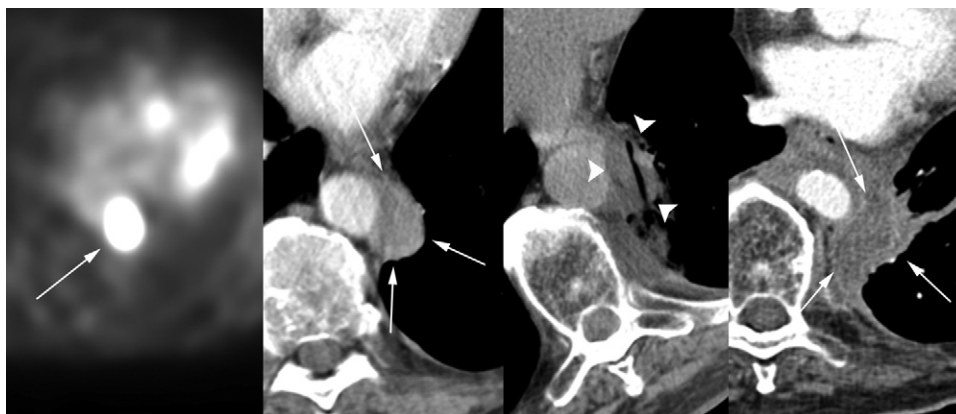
The 68-year-old patient shown in Figure 1 was found to have a [¹⁸F]fludeoxyglucose PET-positive left paraaortic node (image 1, arrow) 4 months after the ablation procedure shown in Figure 1. This enhancing lesion measuring 1.8 × 3.5 × 4.2 cm (image 2, arrows) was treated with cryoablation (image 3, arrowheads), resulting in a resorbed hypodense nonenhancing soft-tissue site on follow-up axial CT (image 4, arrows). As demonstrated in the third image, well demarcated hypodense margins of the ice ball allow safe ablation adjacent to crucial structures such as the aorta.
